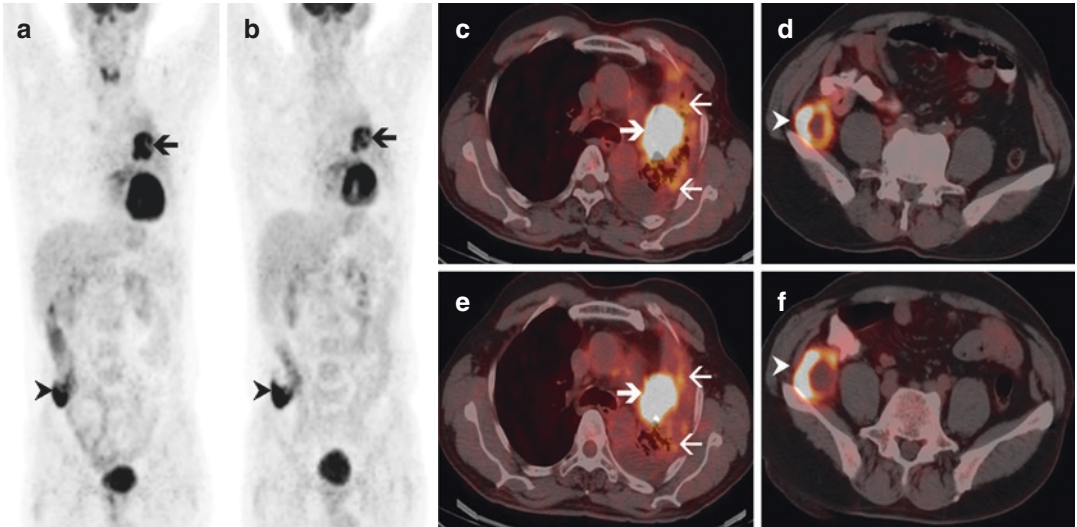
Lung cancer post stereotactic body radiotherapy, showing stable disease. Description: A 59-year-old lady with adenocarcinoma of right lung treated with stereotactic body radiotherapy. Baseline whole-body MIP (a), axial fusion (c) and axial CT images (d) show a right lung lesion (thick arrow). Post-therapy whole-body MIP (b), axial fusion (e) and axial CT images (f) show no response
